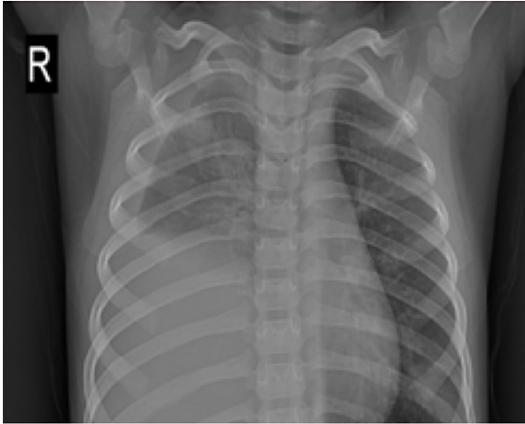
Lobe consolidation in the right lung (chest X-ray).
